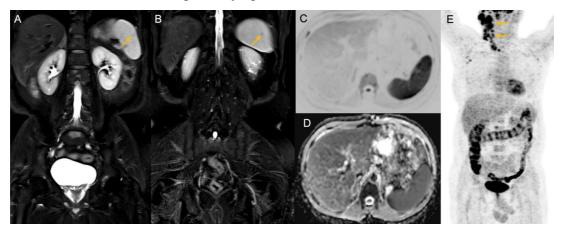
Stage IV on both WB-MRI and PET-CT. A & B. Coronal STIR images showing focal hypointense lesions in the normal-sized spleen (yellow arrows). C & D. Axial DWI image and ADC map do not reveal any focal lesion in the spleen. STIR sequence is better in the detection of small splenic nodules than DWI as the spleen shows physiological diffusion restriction which decreases the DWI sensitivity in lesion detection. E. Coronal MIP PET image showing multiple enlarged FDG avid right cervical lymph nodes. No obvious FDG avid focal lesion was seen in the spleen.
